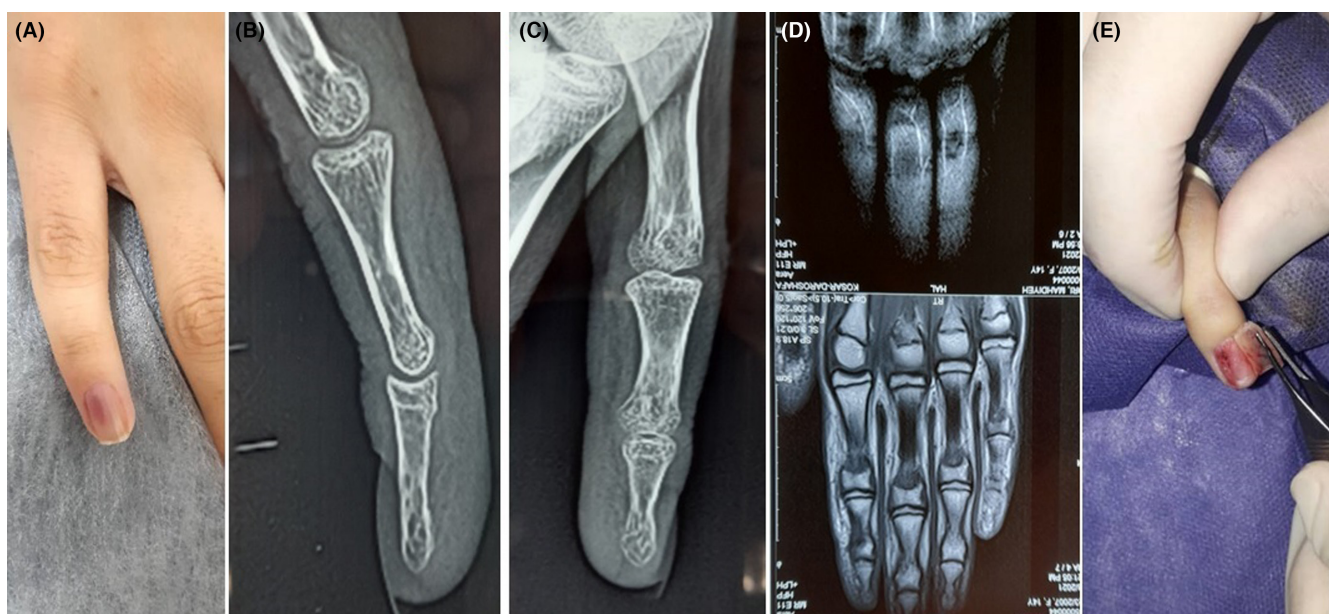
The subungual glomus tumor area was examined physically (A), followed by a plain radiography (lateral [B] and A-P [C] view) and T-1-weighted CT scan (D) of the little finger. After softening the nail plate by placing the distal phalanx of the thumb in a warm water bath at 55°C, the tumor was removed (E).
